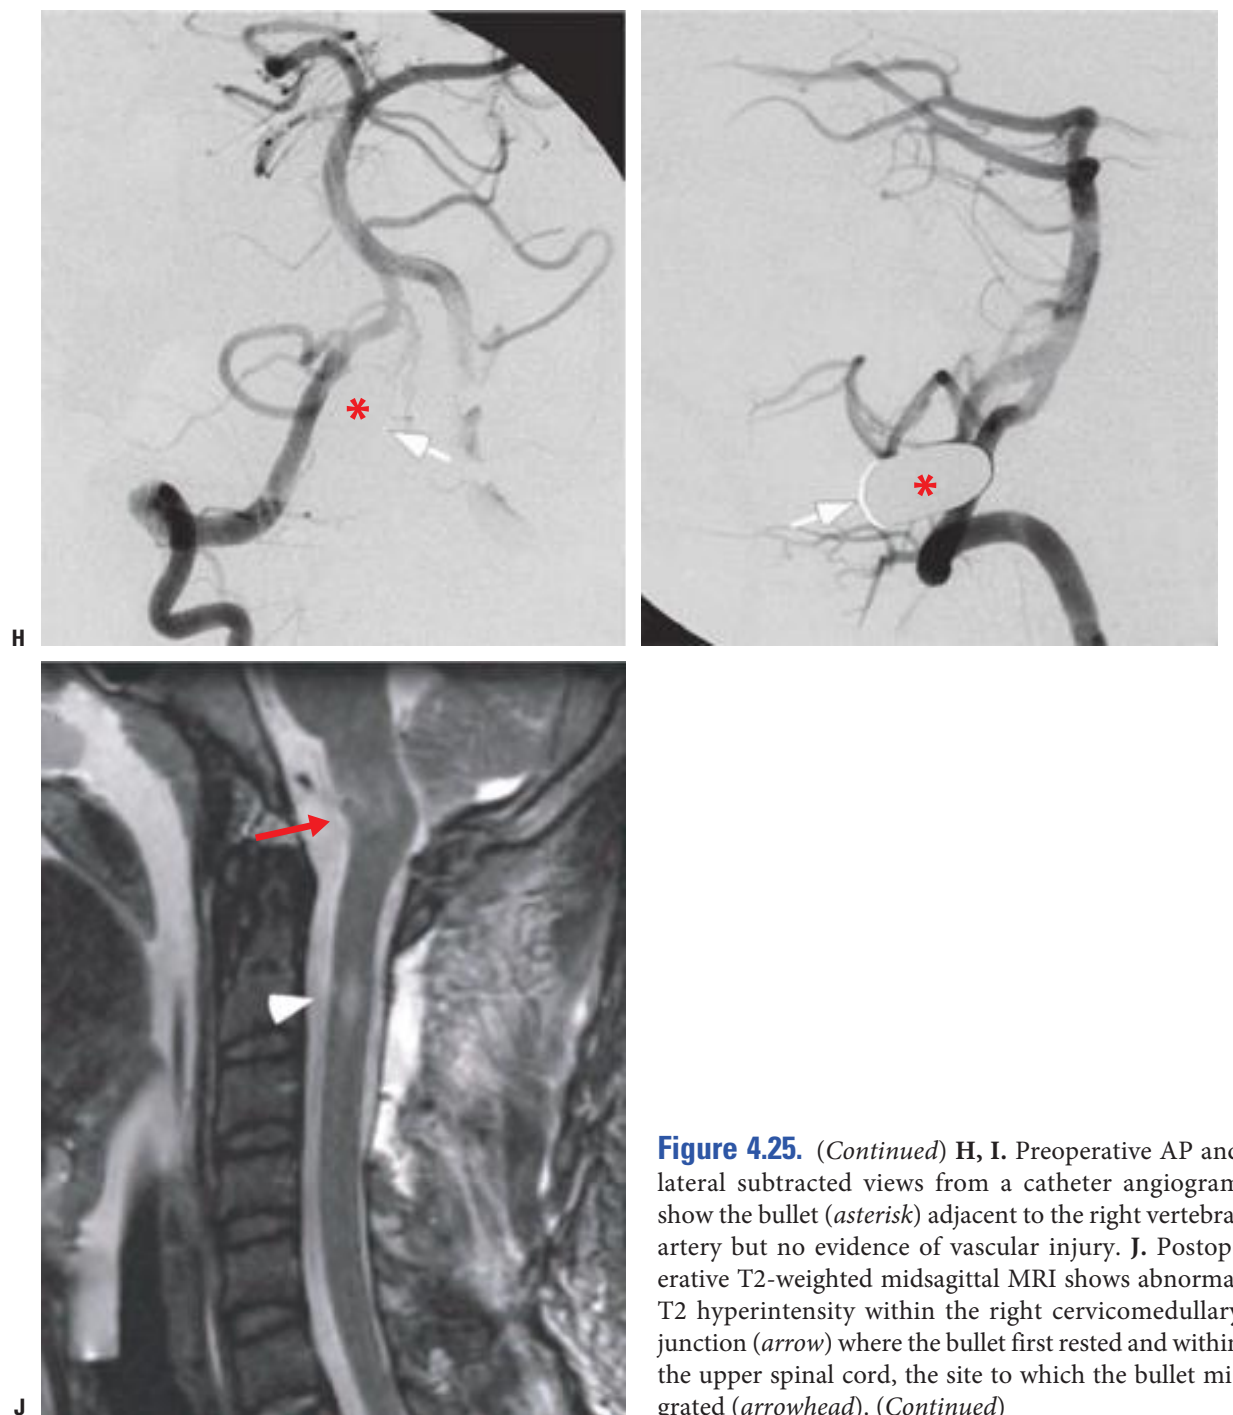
Bullet Migration. This 21-year-old male presented with a left hemiparesis after an acute GSW. The bullet entered the left scapula, traversed the squamous segment of the occiput, and came to rest in the right lateral medullary cistern. His hemiparesis recovered, but 10 days later, he developed abrupt quadriplegia coincident with fall of the bullet into the anterior spinal canal. The bullet was retrieved following a C2–C3 laminectomy, and a postoperative MRI confirmed signal change in the cord at the level where the bullet had resided. The patient made a good neurologic recovery. A. Midsagittal reformat CTA on admission shows a bullet posterior to the inferior aspect of the clivus (*red arrow*). Metallic artifact makes it difficult to assess its precise margins. A small fracture of the occiput is also noted (*yellow arrow*). B. Corresponding lateral scout view. Note the lack of deformity of the bullet, confirming its jacketed nature. C. Ten-day follow-up scout image shows interval migration of the bullet into the upper cervical spine (*arrow*). (*Continued*)
